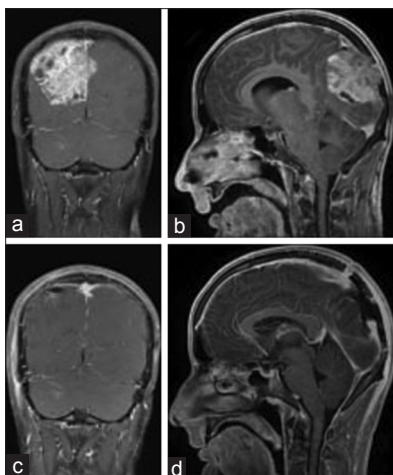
A coronal T1-weighted contrast-enhanced MR scan, and midline sagittal 3D incoherent gradient echo MR scans 2 weeks prior to (a,b), and 1 month following the operation (c,d)
